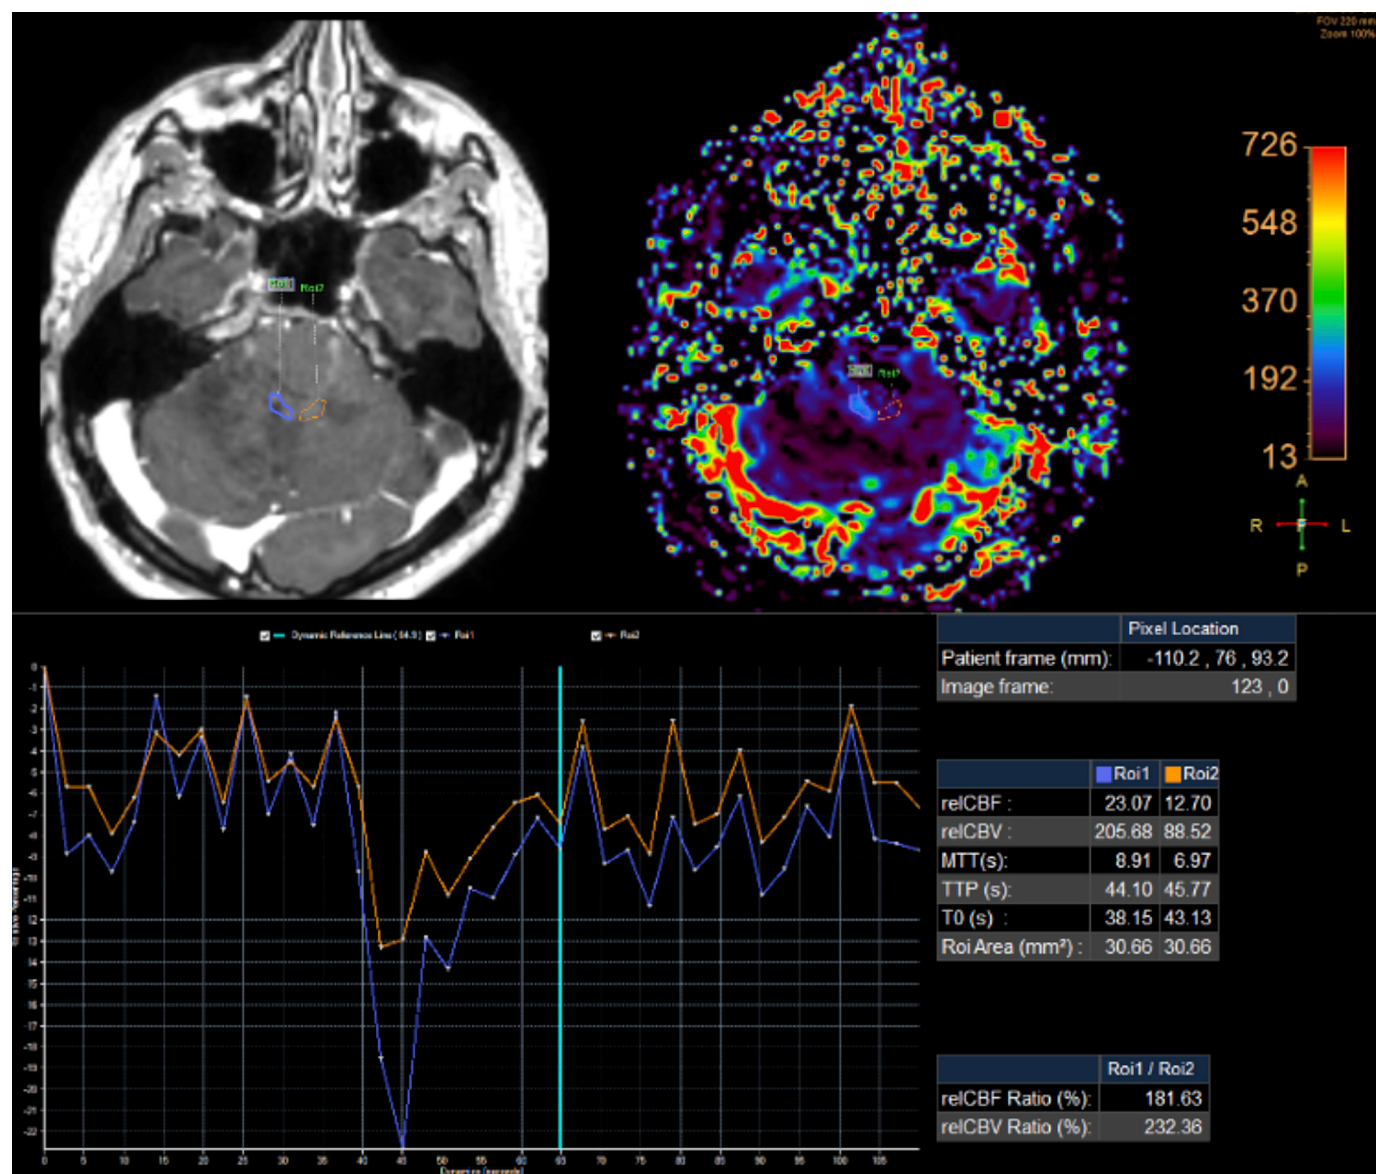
MRI examination of a patient diagnosed with Glioblastoma (G4). Molecular characteristics: *IDH1*-wt, *MGMT* methylated, *EGFR* amplification, *CDKN2A* homozygous deletion, 1p19q non-codeleted, *TERT* pathogenic variant. Imaging analysis: rCBV = 13.2; rCBF = 12.7. A. T1 post-contrast. B. DSC MRI - CBV map. C. DSC MRI - histogram. D. DSC MRI - perfusion features.
